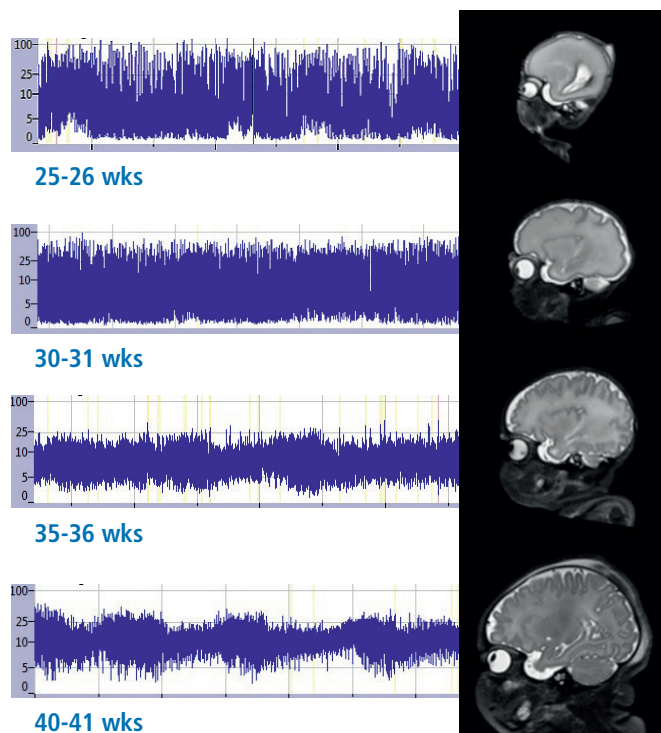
aEEG background pattern at four different time points showing the maturation over time, where the background patterns goes from a broad amplitude to a smaller bandwidth with sleep-wake cycling. The corresponding T2 weighted MRI images in the sagittal view are showing a near smooth brain at 25 weeks, with a brain folded similar to the adult brain at term age.
